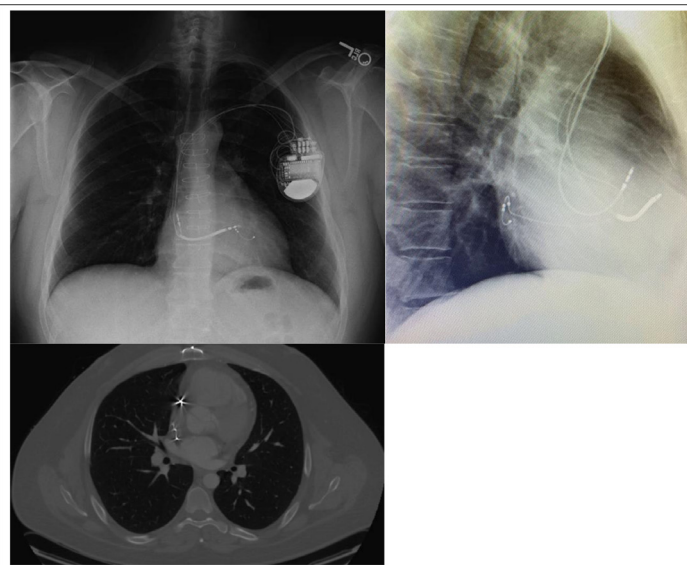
PA and Lateral Chest X-Ray and CT of the Chest following CRT-D upgrade of dual chamber pacemaker. Please note the anterior free wall location of the RV lead and minimal lead separation.
